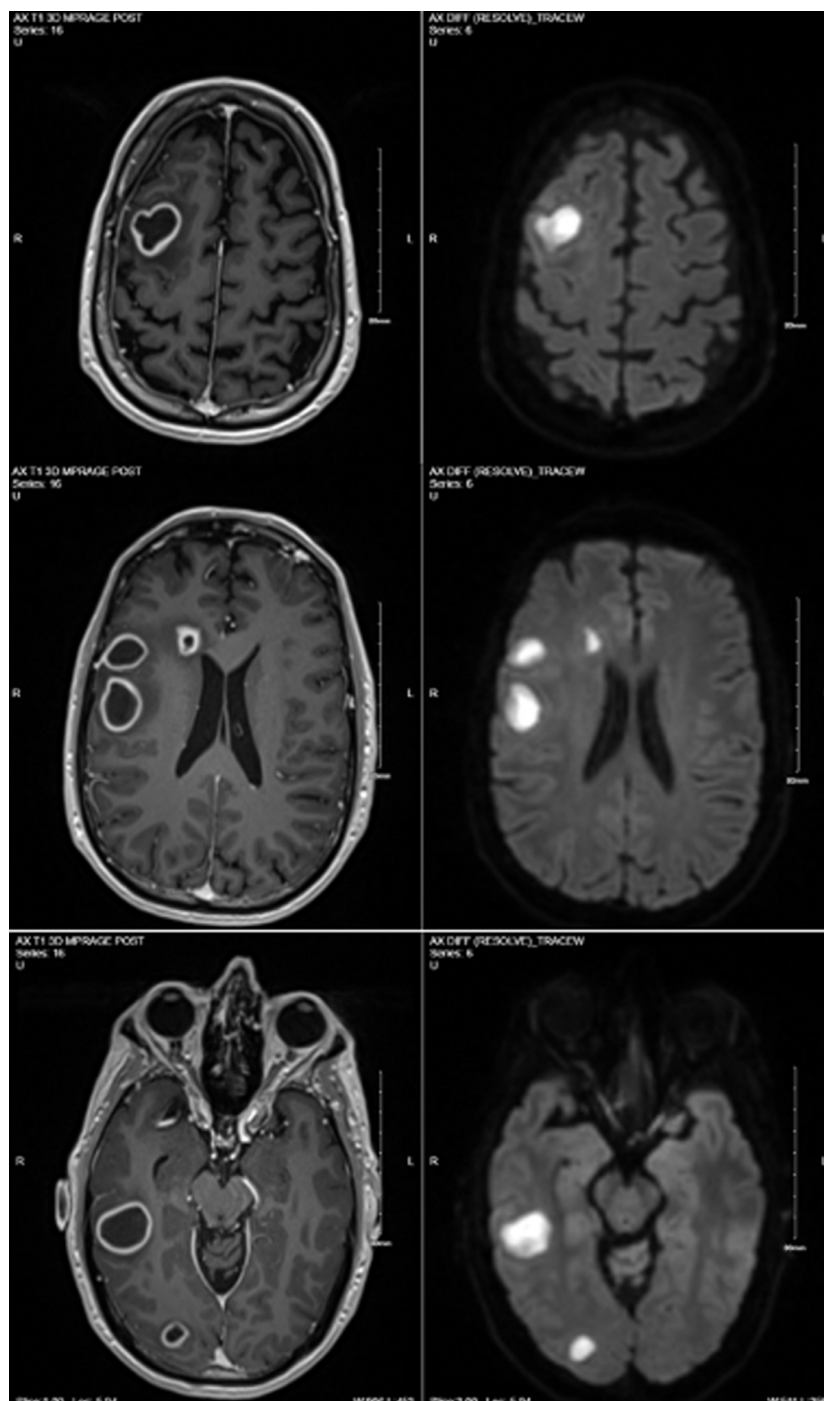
Axial MRI T1-weighted images with contrast (left) and diffusion-weighted images (right) showing multiple intracranial abscesses in the right cerebral hemisphere.
